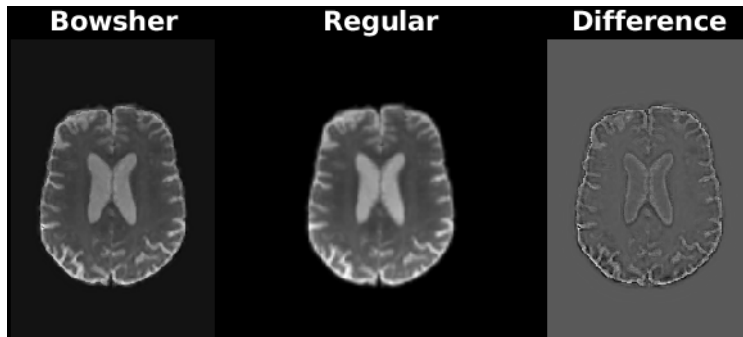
The result of the reconstruction of the DWI with the Bowsher prior to the left, the regular registered DWI before reconstruction in the center, and the difference between the images to the right.
